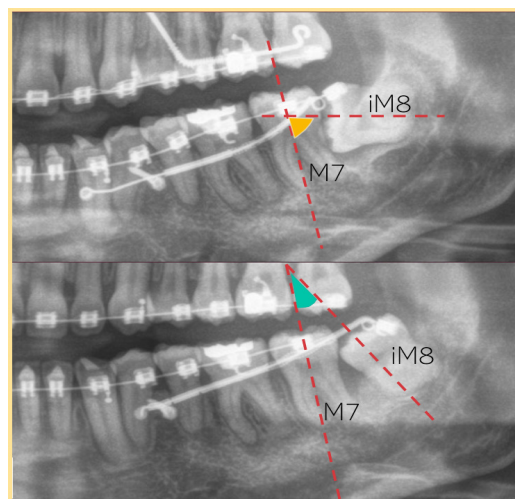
Panoramic radiograph; before and after treatment of uprighting 3<sup>rd</sup> molar
